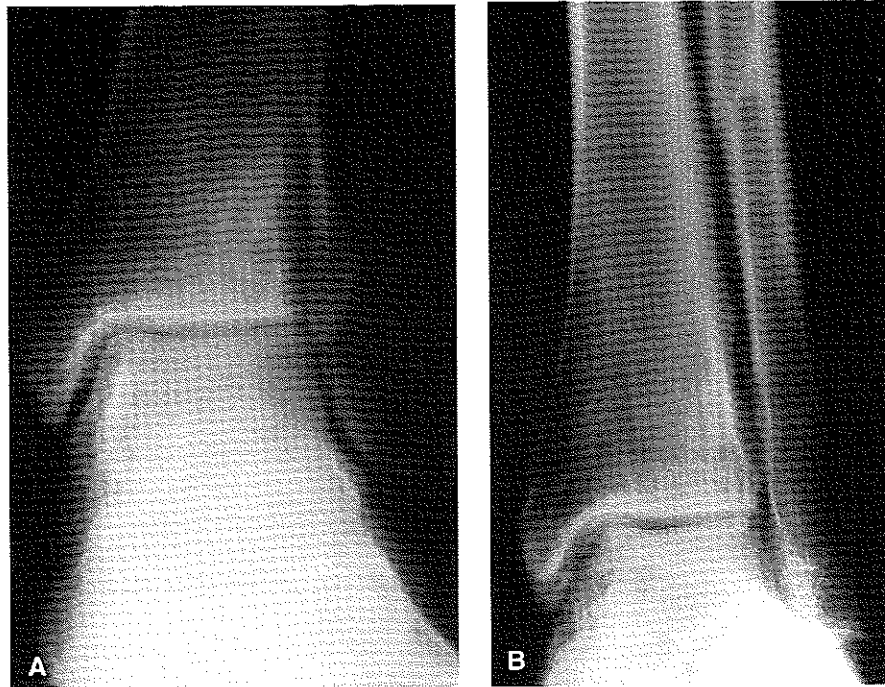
A chronically symptomatic medial malleolar nonunion 2 years after open reduction of a pronation external rotation ankle fracture. A: An anteroposterior radiograph of the ankle shows an ununited collicular fracture of the medial malleolus. Notice the fine line lucency with a subtle sclerotic border separating the fracture from the medial malleolus. B: Internal oblique ankle view helps to delineate the ununited fracture fragments of the malleolus as well as degenerative changes and calcification within the medial gutter of the ankle, the syndesmosis, and along the interosseous membrane. The proximal fibular fracture is easily appreciated on this view.
